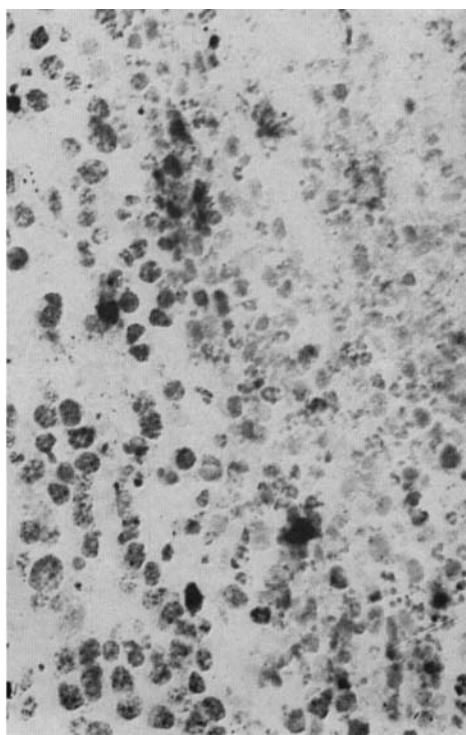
48 h after roentgen irradiation (1 000 R); an appearance almost similar to the untreated tumour, the peripheral cells with a slightly more intense positive reaction, however (215 $\times$).
